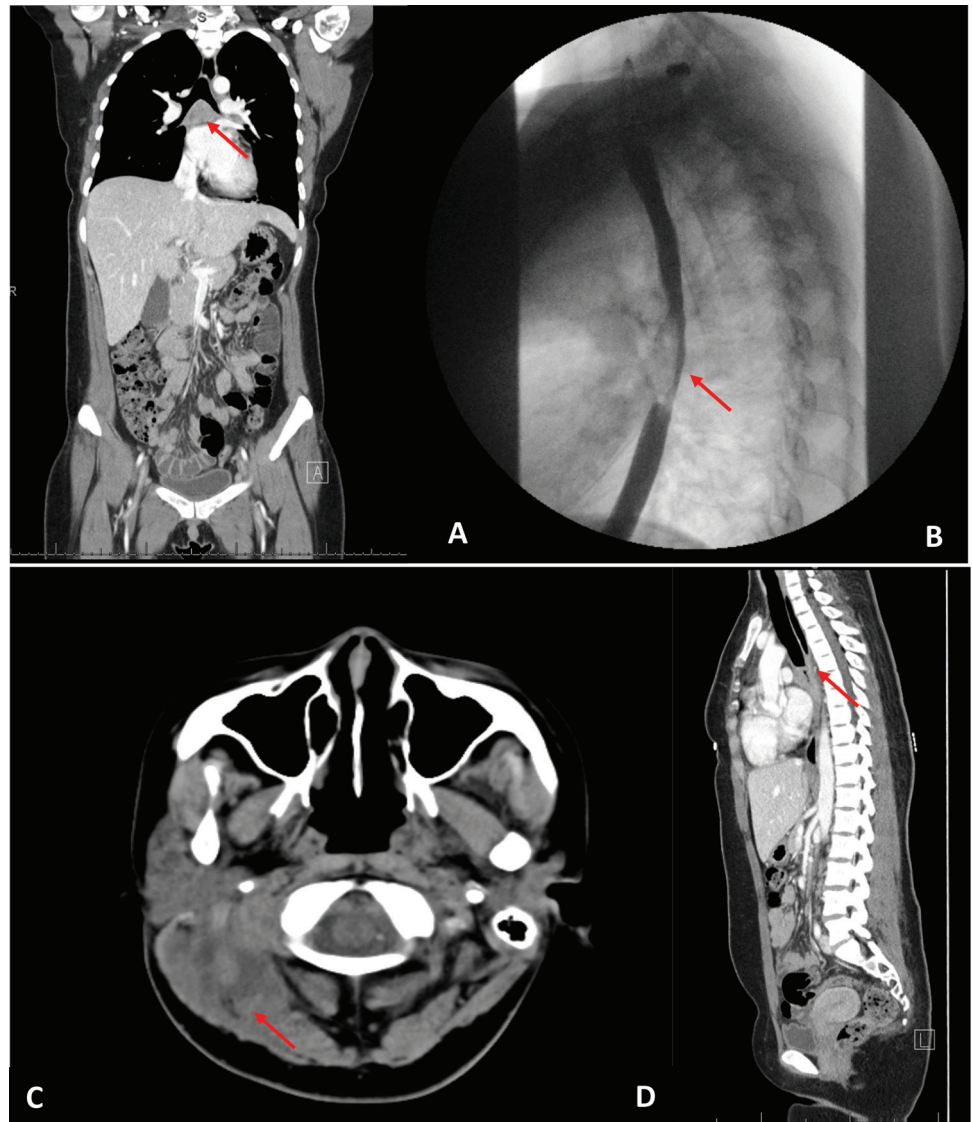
Diagnostic imaging. (A) Coronal computed tomography (CT), showing a subcarinal mass. (B) A barium esophagram, demonstrating esophageal narrowing. (C) A maxillofacial CT, showing a soft-tissue mass. (D) Sagittal CT, demonstrating esophageal obliteration.
